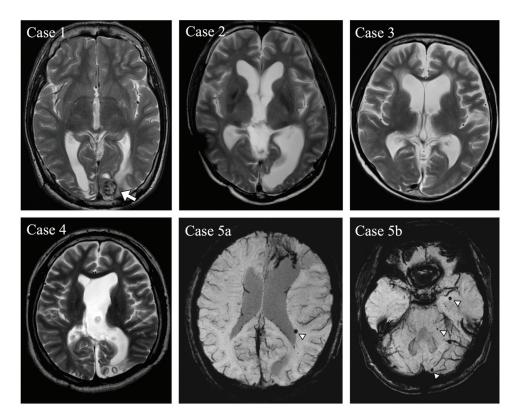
MR imaging findings of each patient. Axial T2-weighted image of Case 1 showing a radiation-induced cavernoma in the left occipital lobe (arrow). Axial T2-weighted images of Cases 2 and 4 showing left occipital cortical abnormalities, which implied the damage was caused by brain surgery for pineal tumor. Axial T2-weighted image of Case 3 showing diffuse brain atrophy probably due to radiotherapy. Susceptibility-weighted images of Case 5 (Case 5a and 5b) showing multiple microbleeds (arrowheads). MR: magnetic resonance.
